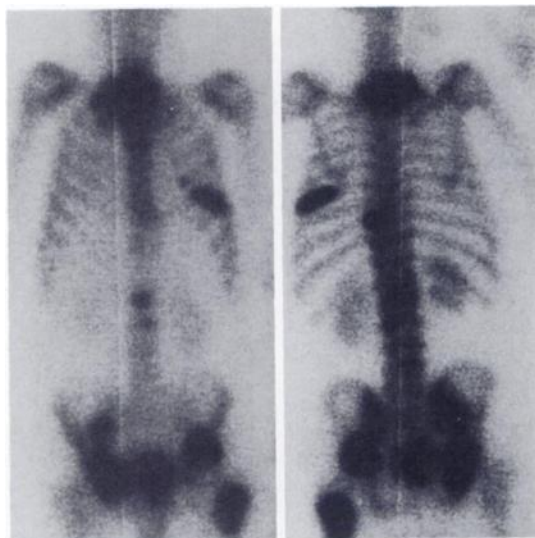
Anterior (left) and posterior (right) total-body scintigrams performed 2½ hr after injection of Tc-99m MDP, showing multiple focal areas of increased activity in keeping with metastatic lesions in lower cervical spine, upper, mid, and lower thoracic spine, acetabular regions of pelvis bilaterally, right ilium, left intertrochanteric regions, and proximal shaft of left femur. No definite primary tumor was known at this stage.
